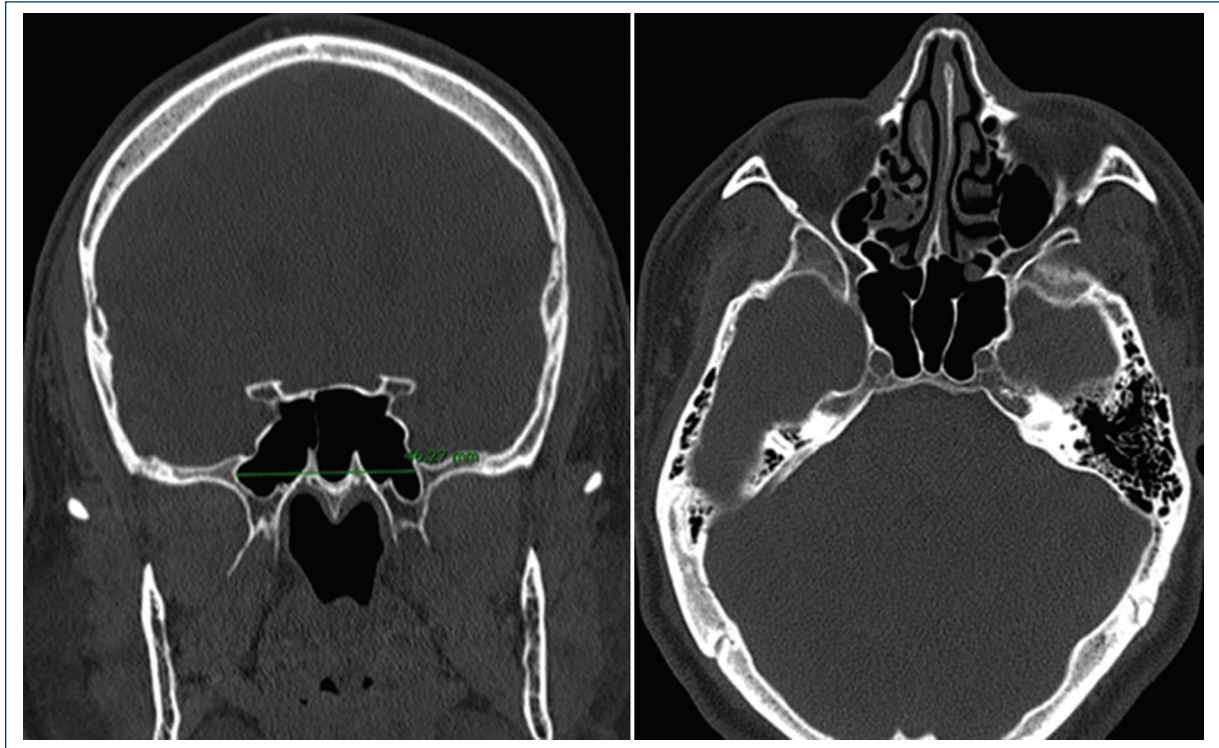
Simple computed tomography of the nose and paranasal sinuses in axial and coronal views detailing surgical risk III B V B N based on the proposed classification.
